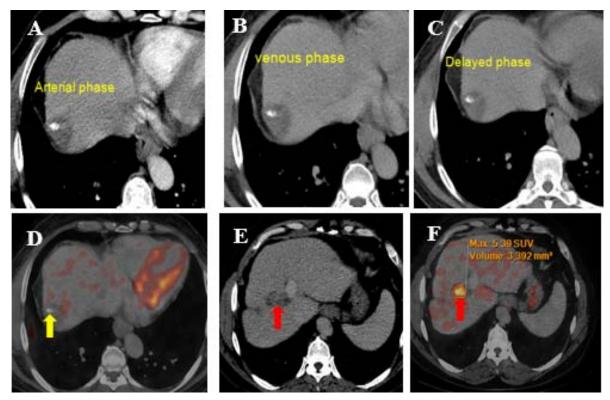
Sixty eight years old male patient, presented with elevated alpha fetoprotein serum level (213 ng/mL) and had history of HCC treated by TACE. PET/CT was needed for assessment. A, B, C CECT phases show no abnormality at site of TACE. D fused PET/CT images well ablation of the chemoemoblized lesion (yellow arrow). E Axial CECT shows portal vein thrombus (Red arrow). F axial fused PET/CT image shows hyper metabolic portal vein thrombus denoting tumoral thrombus other than benign PV thrombus.
